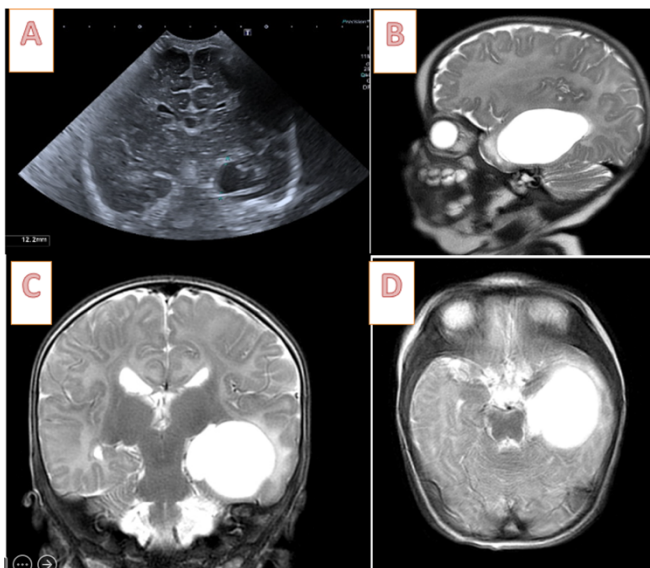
Preoperative images. (A) Initial transfontanellar ultrasound on September 9, 2024: an extra-axial cyst measuring 15 mm is visualized in the left temporal fossa, compatible with an arachnoid cyst. (B–D) Sagittal, coronal, and axial MRI scans on December 4, 2024 (T2 FSE PROPELLER sequence) showing enlargement of the left temporal cystic structure (5 × 3.5 × 3 cm) compared with the previous ultrasound, currently suggesting entrapment of the temporal horn of the left lateral ventricle. Vasogenic edema is observed in the perilesional white matter.
